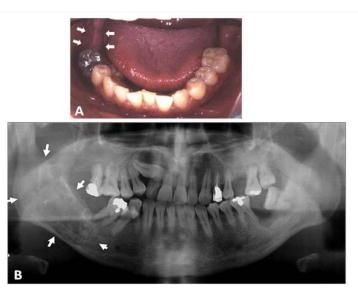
8 The patient reported no symptoms in his mouth including the mandibular area, and on clinical examination no swelling could be detected on the right side of the jaw, and the oral mucosa appeared normal (Figure 1A) . a pano- ramic radiograph revealed an extensive radiolucent and multilocular area with imprecise borders that extended from the right posterior mandibular body to around the root of tooth #46, and exhibited a "soap bubble" appear- ance (Figure 1B) . (Kawase-Koga et al.,2014)
